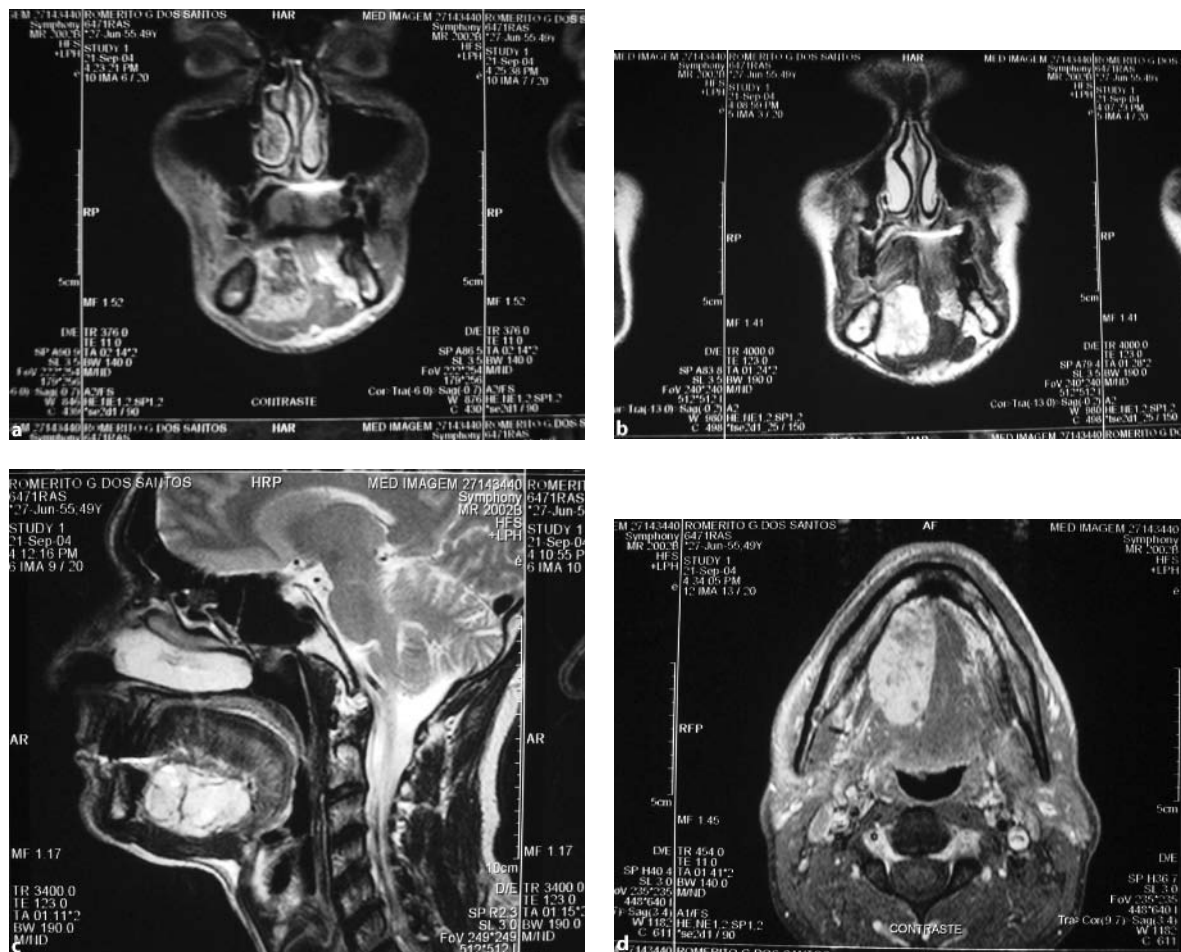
T1-weighted coronal MRI images (with and without contrast) of a heterogeneous sublingual mass in close relationship with the inner part of the mandible (a) and involving the suprahyoid muscles (b). T2-weighted sagittal MRI images revealing its higher anteroposterior diameter (c). T1-weighted axial MRI revealing the relationship of the tumor and the lingual muscles, consistent with an adenoid cystic carcinoma of the right sublingual gland (d)
